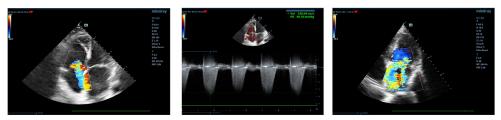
c.1. Moderate tricuspid regurgitation (left and middle image; Vmx=3.5 m/s; color and CW Doppler at tricuspid valve level, 4-chambers view) due to secondary pulmonary hypertension consecutively to a left cardiac pathology: severe mitral regurgitation (right image-color Doppler, 4-chambers view)
